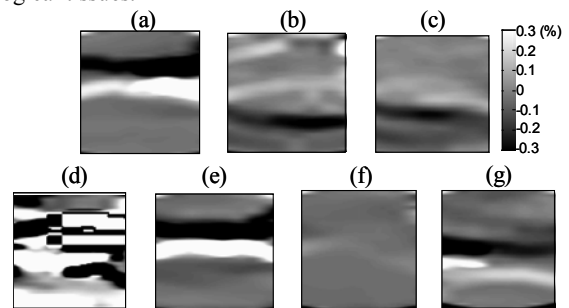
Cardiac elastograms in an in vivo long-axis parasternal view in a normal subject at systole ((a) 8%, b) 23%, c) 38%), d) 53% (ejection), e) 67% (fast filling), f) 75% (diastasis) and g) 97% (isovolumic contraction) of the cardiac cycle. Grayscale shows the strain (in %). The epicardium is at the top and the ventricular cavity below.
